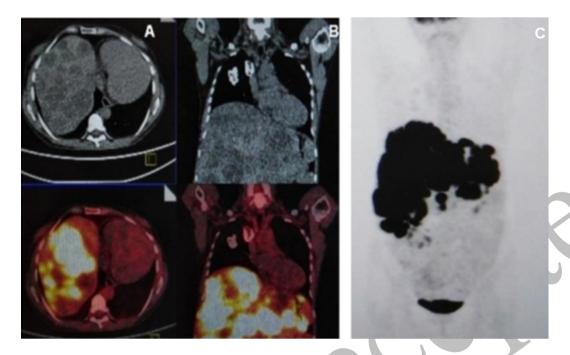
A – axial CT, fused PET/CT, B – coronal CT, fused PET/CT, C – (MIP) PET images of elevated right semi-diaphragm with heart dislocation to left hemithorax
